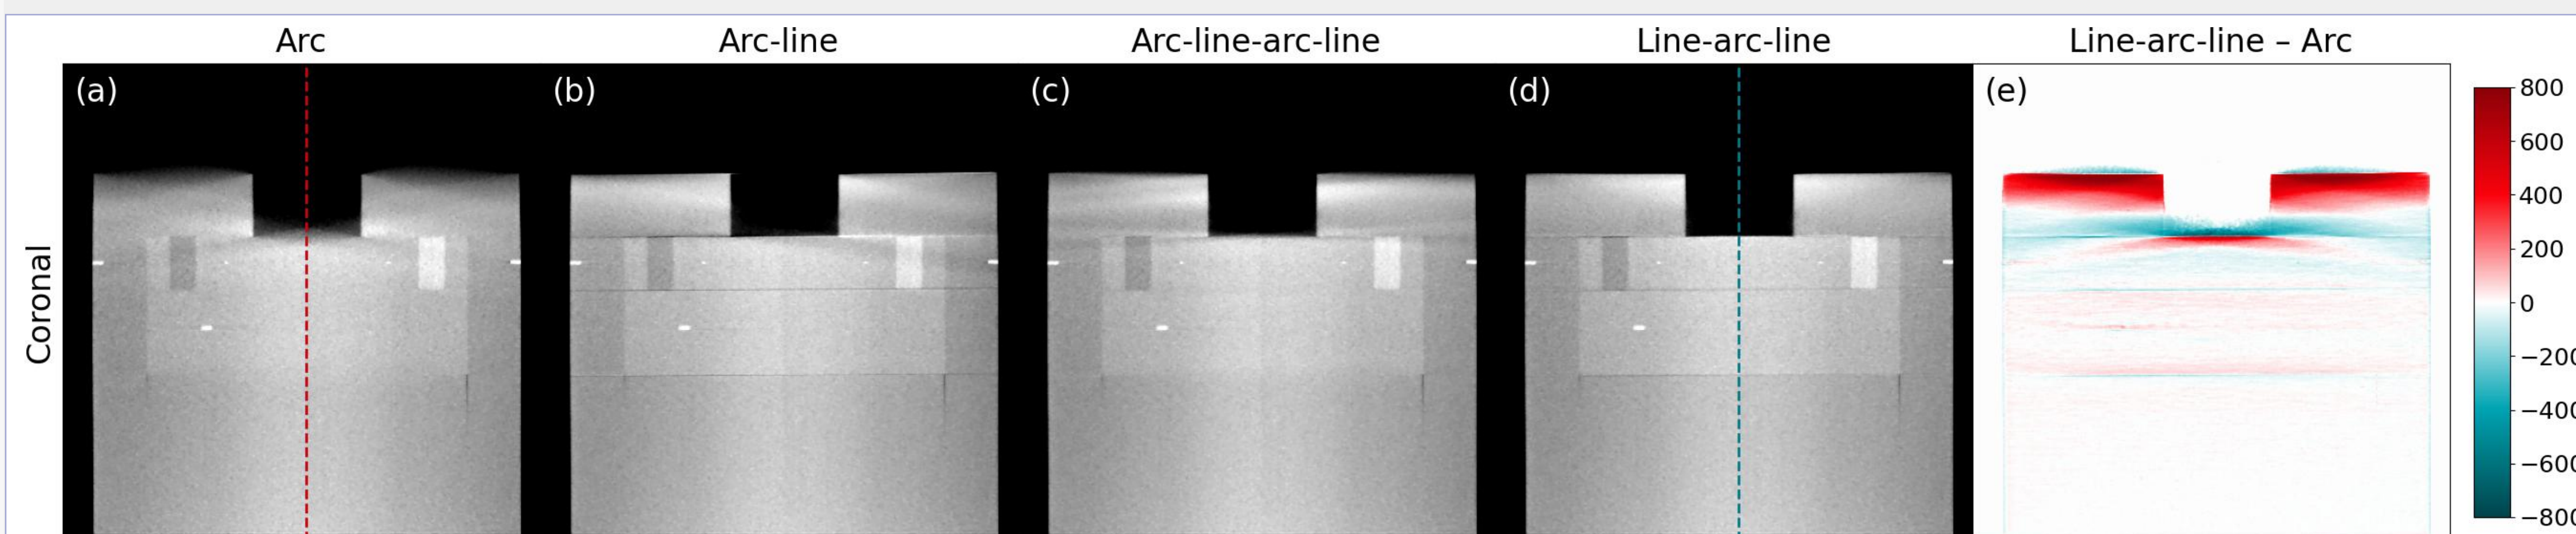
Slices from CBCT reconstructions of a Catphan 503 for different scan trajectories (window: [-1000, 500] HU), with the difference between the line-arc-line and arc trajectories in (e). Dashed lines indicate where the axial profiles are taken.
